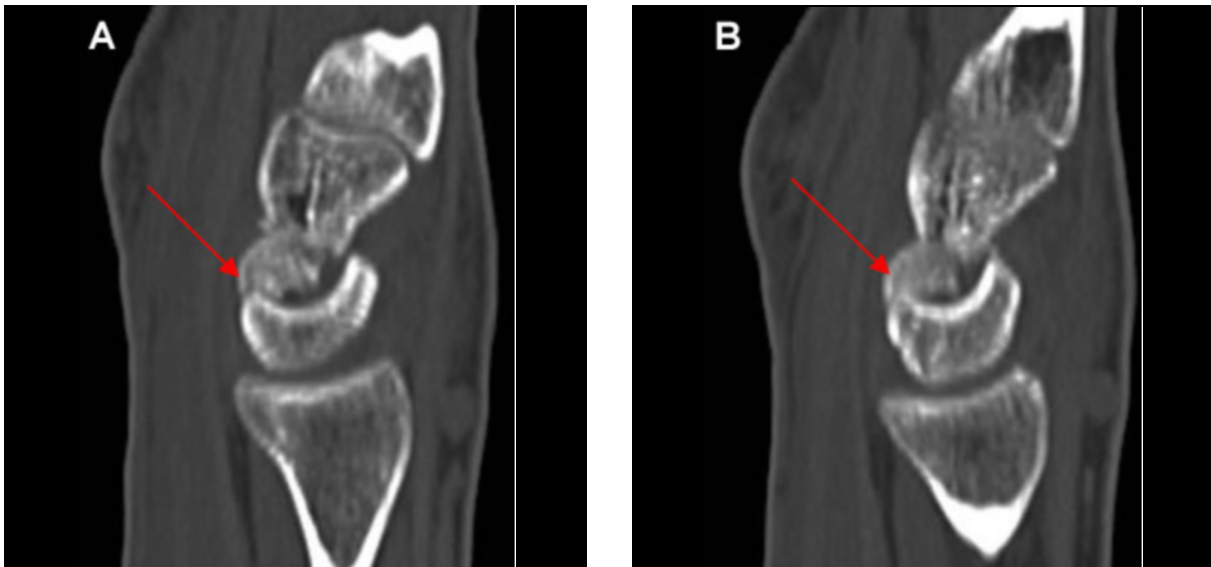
Sagittal CT images demonstrate the capitate fracture (arrows).
